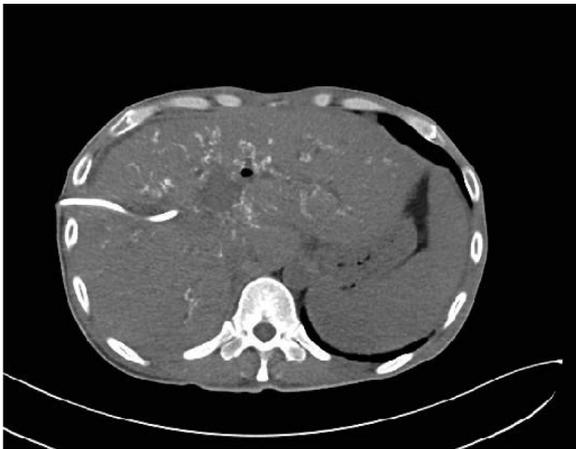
Multidetector CT showed diffuse calcification of the bile duct walls.
